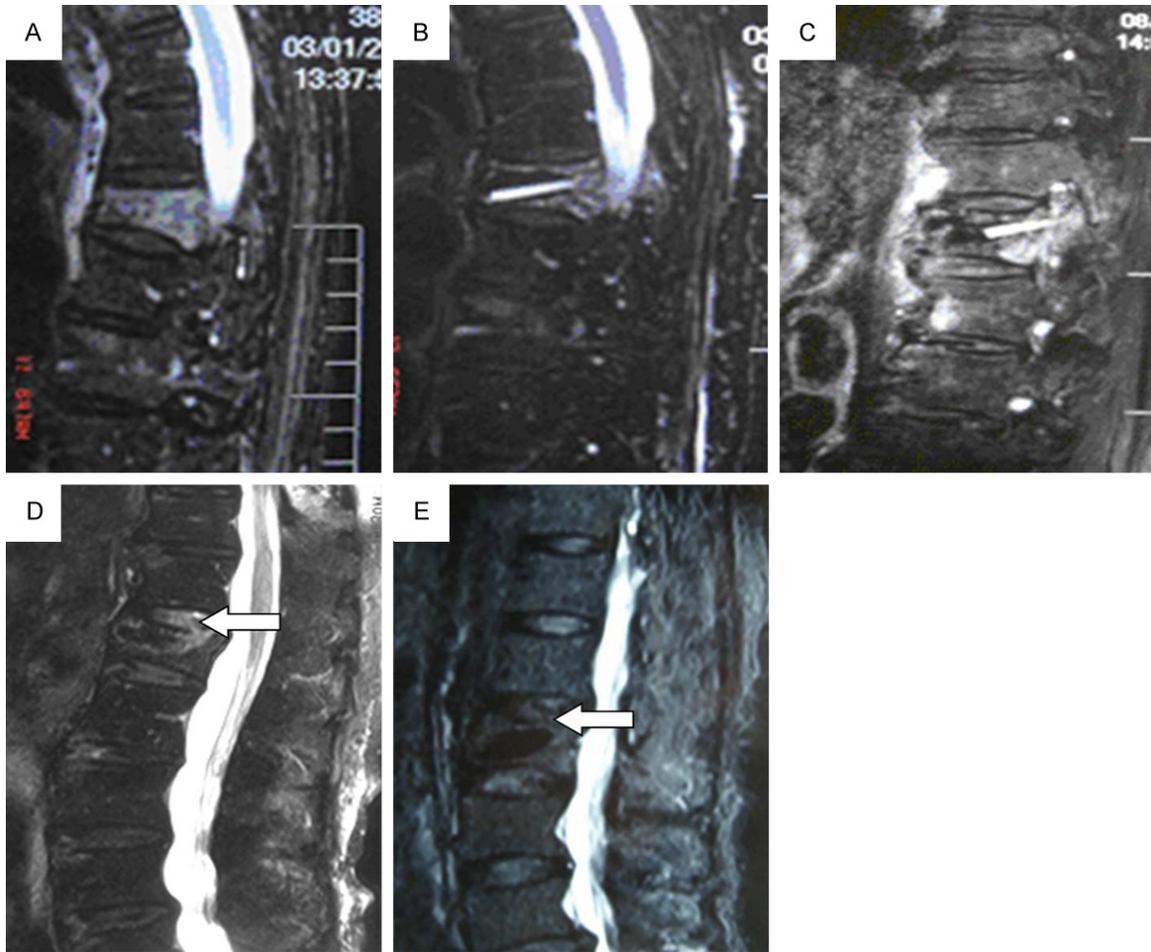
MRI examination of perioperative vertebral body. (A) Preoperative T_2 WI+FS hyperintense edema in the vertebral body. (B) T_2 WI+FS hyperintensity in the vertebral body around the bone at 2 weeks postoperation. (C) High signal still exists in T_2 WI+FS vertebral body at 3 months after operation but significantly decreases. (D) High signal in T_2 WI+FS vertebral reduces but still exists at 6 months after operation. (E) Signals in T_2 WI+FS vertebral body disappeared completely after 10 months of surgery, and no high signal detected in comparison with the surrounding vertebral body. Note: bone cements in (B-E) are all low signal, the slash-like body high signal in (B, C) is the bone tunnel after Kp puncture.
